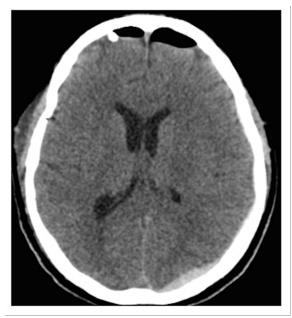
CT brain demonstrates pneumocephalus and left subdural bleed.
